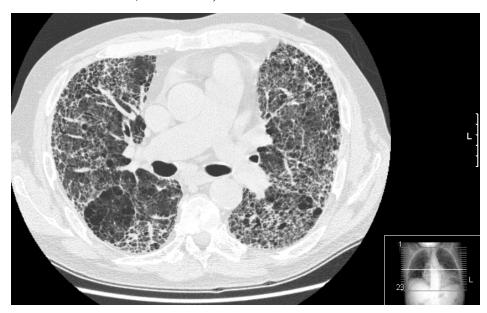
shows HRCT of lung showing extensive fibrosis possibly from usual interstitial pneumonitis. There is also a large emphysematous bulla.
